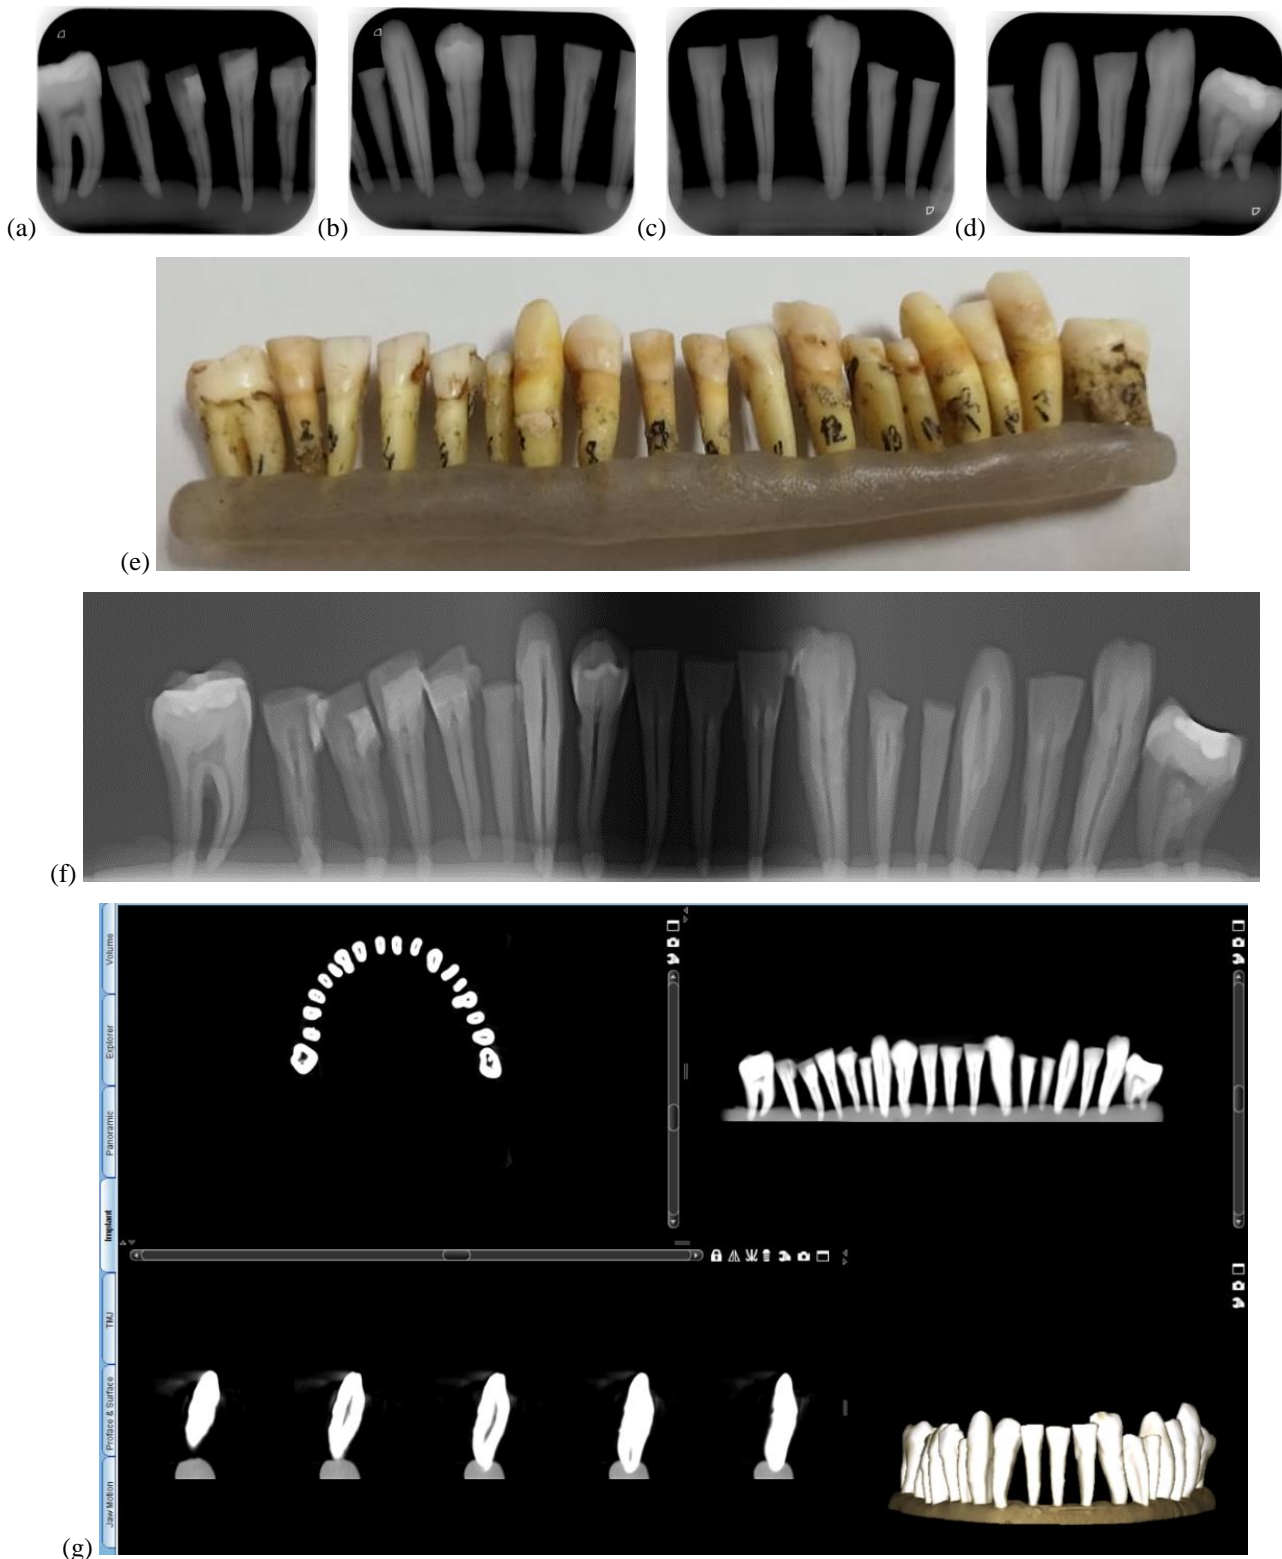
Pictures from (a) to (d) are intraoral radiographs of extracted teeth from picture (e). (f) is the panoramic radiography and (g) is the 3D CBCT of the same extracted teeth.
